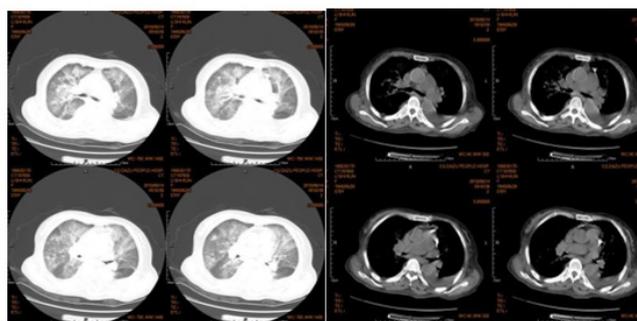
Chest computed tomography scans show increased bronchial vascular bundles in both lungs, disorganized alignment, diffuse large hyperdense shadows in both lungs with blurred boundaries, bilateral pleural thickening, and a small amount of bilateral pleural effusion.
